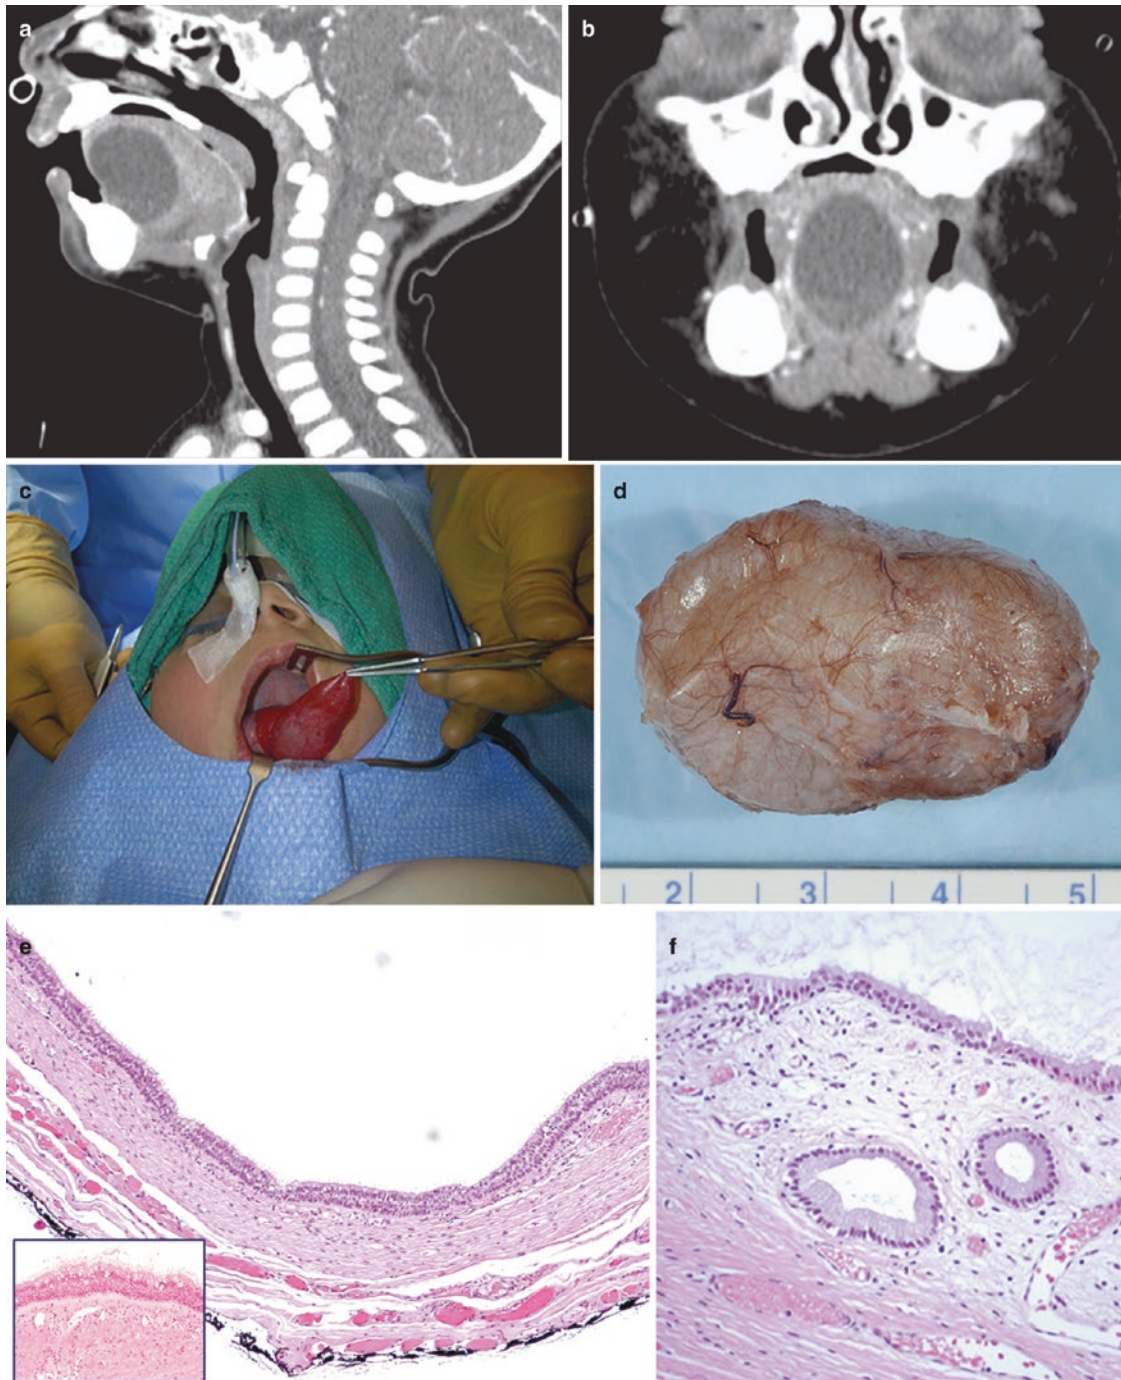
(a) Sagittal T1 MRI showing cyst in tongue. (b) Coronal T1 MRI showing cyst in tongue. (c) Large cyst with well-defined capsule at surgery. (d) Gross appearance of cyst. (e) The lining consisted mainly of pseudostratified respiratory ciliated epithelium and the cyst wall of fibrovascular connective tissue. The cyst wall was partially surrounded
